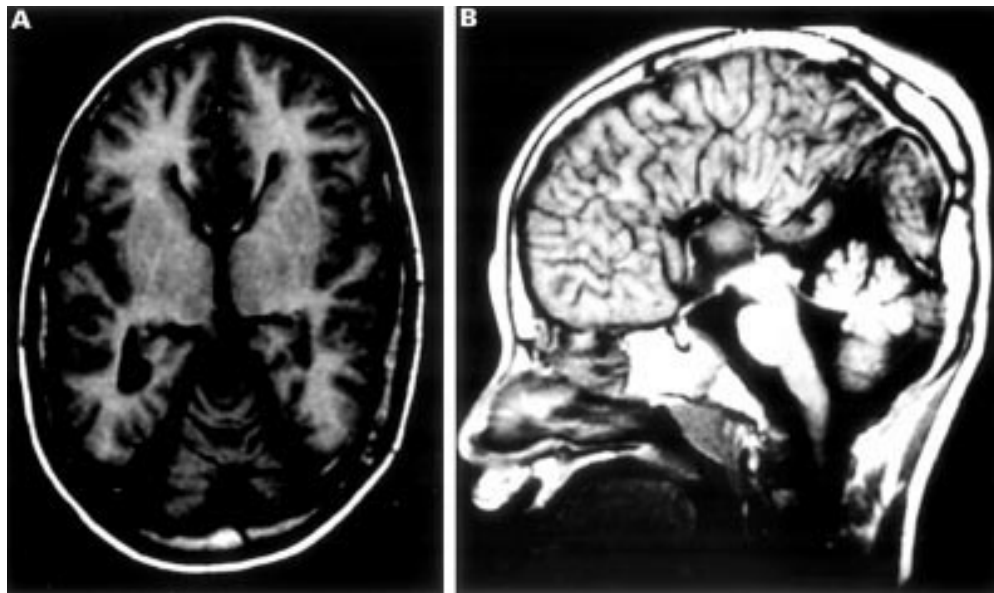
MRI findings. (A) An axial section showing hypoplasia of the medial side of the occipital lobes. (B) A sagittal section showing complete ACC.
